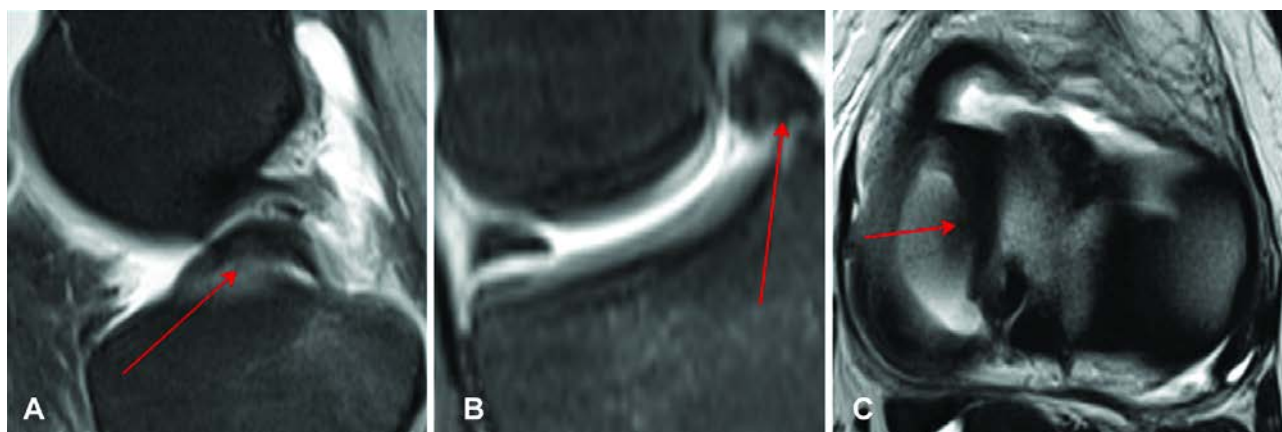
MRI scans of the right knee in a 18-year-old patient A. showing: A – sagittal view demonstrating additional hypointense structure at the posterior cruciate ligament (PCL duplications); B – coronal view demonstrating displaced meniscus in intercondylar notch; C – transverse view demonstrating displaced meniscus in the central aspects of the joint
